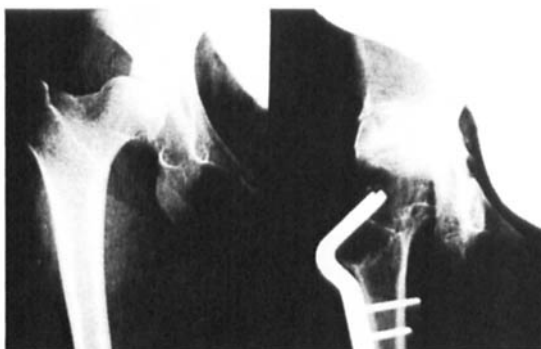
Case 4. Dysplastic acetabulum with varus deformity of the femoral head. Left: Preoperative radiograph at aged 22 years. Right: 4 years after combined rotational acetabular osteotomy and valgus osteotomy of the femur.
